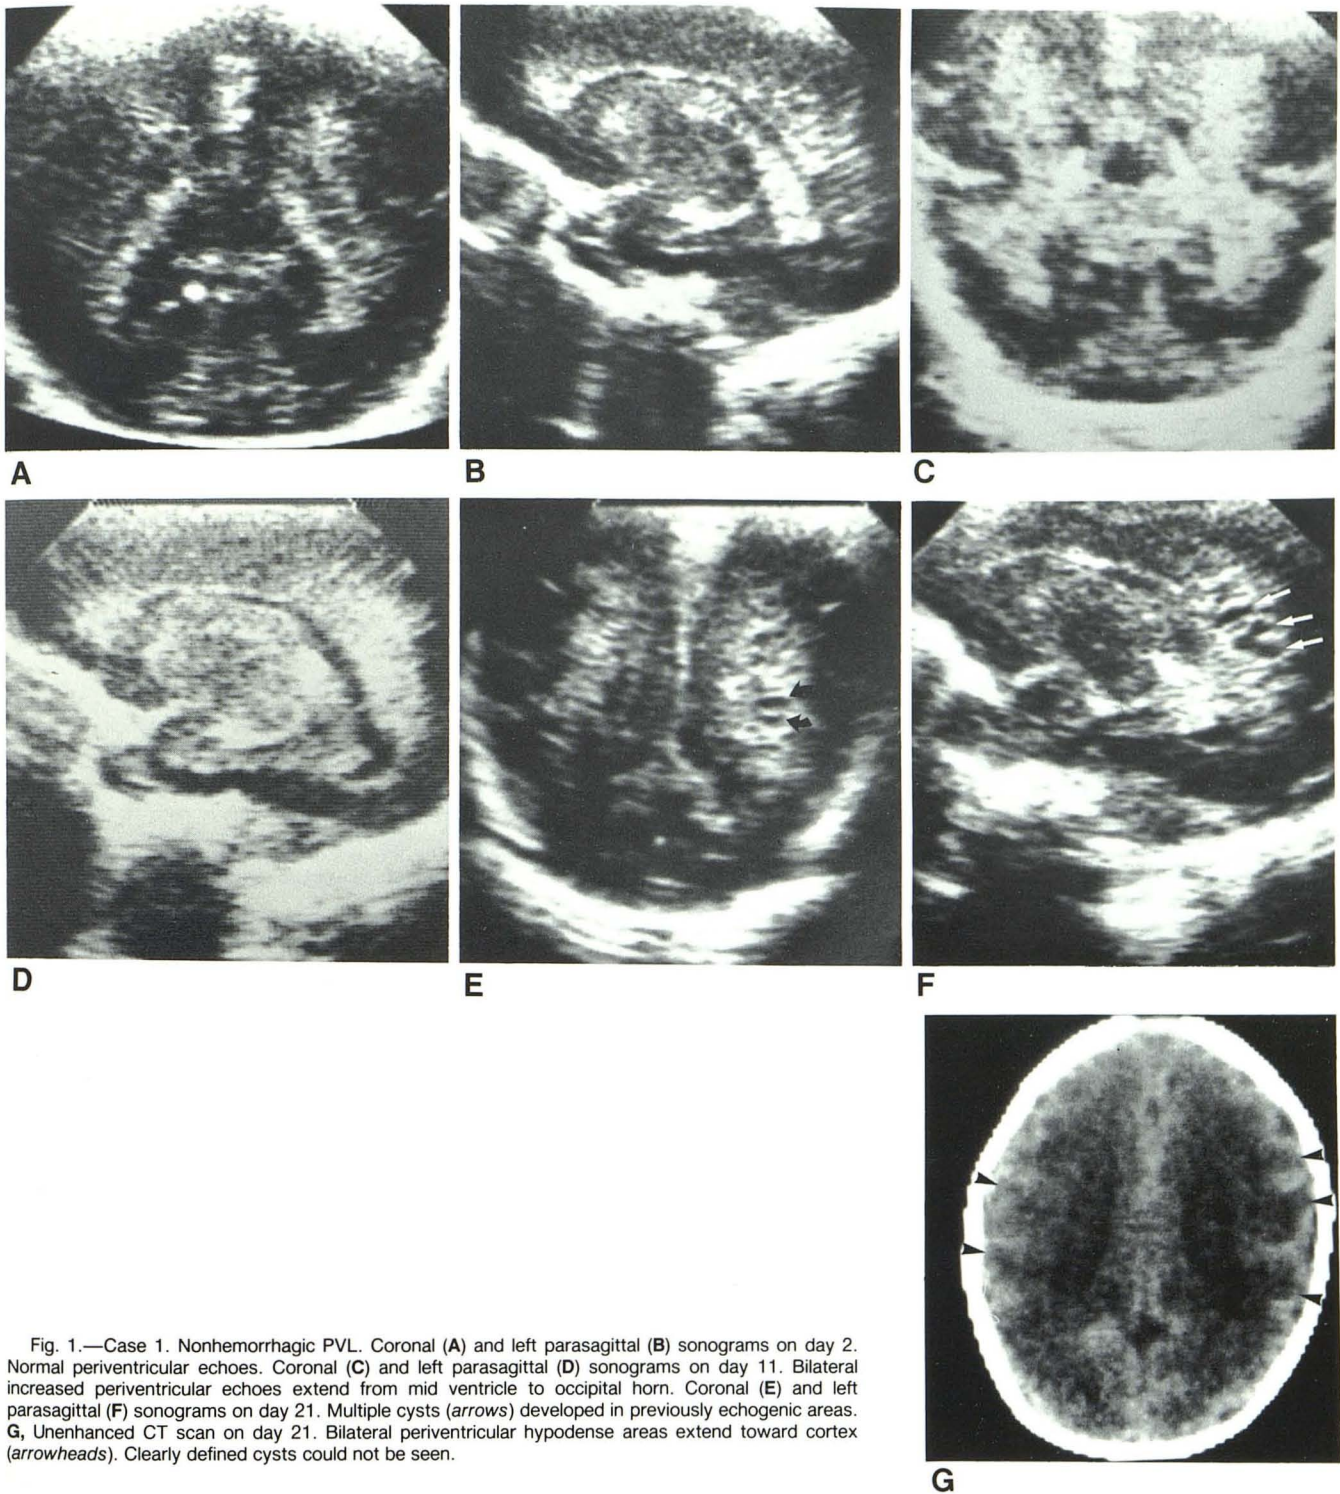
Case 1. Nonhemorrhagic PVL. Coronal (A) and left parasagittal (B) sonograms on day 2. Normal periventricular echoes. Coronal (C) and left parasagittal (D) sonograms on day 11. Bilateral increased periventricular echoes extend from mid ventricle to occipital horn. Coronal (E) and left parasagittal (F) sonograms on day 21. Multiple cysts (arrows) developed in previously echogenic areas. G, Unenhanced CT scan on day 21. Bilateral periventricular hypodense areas extend toward cortex (arrowheads). Clearly defined cysts could not be seen.
